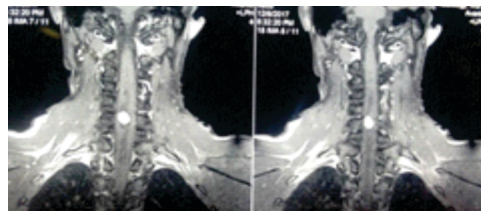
Preoperative MRI Coronal with Contrast
